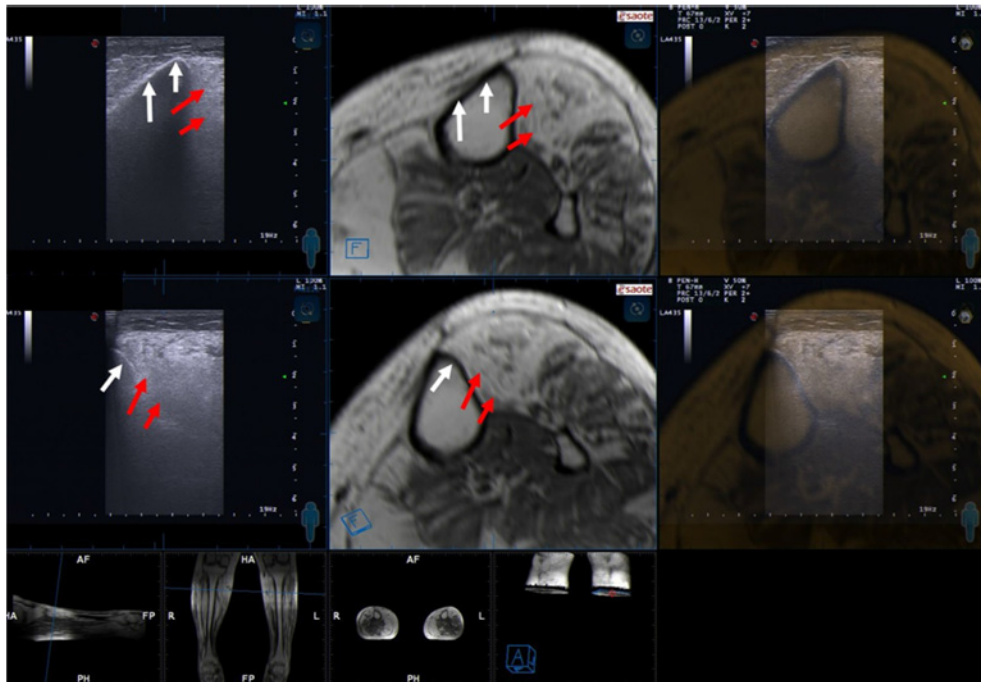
Top and middle row: Cross-sectional insonation of the left lower leg, corresponding MRI and fusion image. Top left: B-mode image of the tibial bone (white arrows) and hyperechogenic Musculus tibialis anterior (red arrows). Note the atypical bright grey B-mode aspect of the muscle. Top middle: corresponding cross-sectional MRI image demonstration almost white muscle aspect. Top right: overlay image of both imaging modalities, demonstrating excellent congruence of ultrasound and MR image. Middle left: ultrasound position turned more laterally visualizing a greater area of the muscle parenchyma – note the continuing excellent matching.
